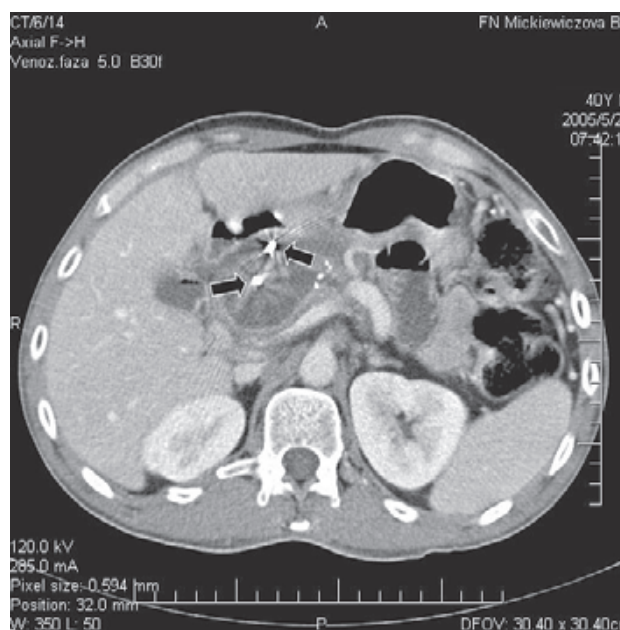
The transcatheter arterial embolization was performed using steel coils. CT shows that the pseudoaneurysm decreased in size. Arrows mark some of the placed steel coils.
